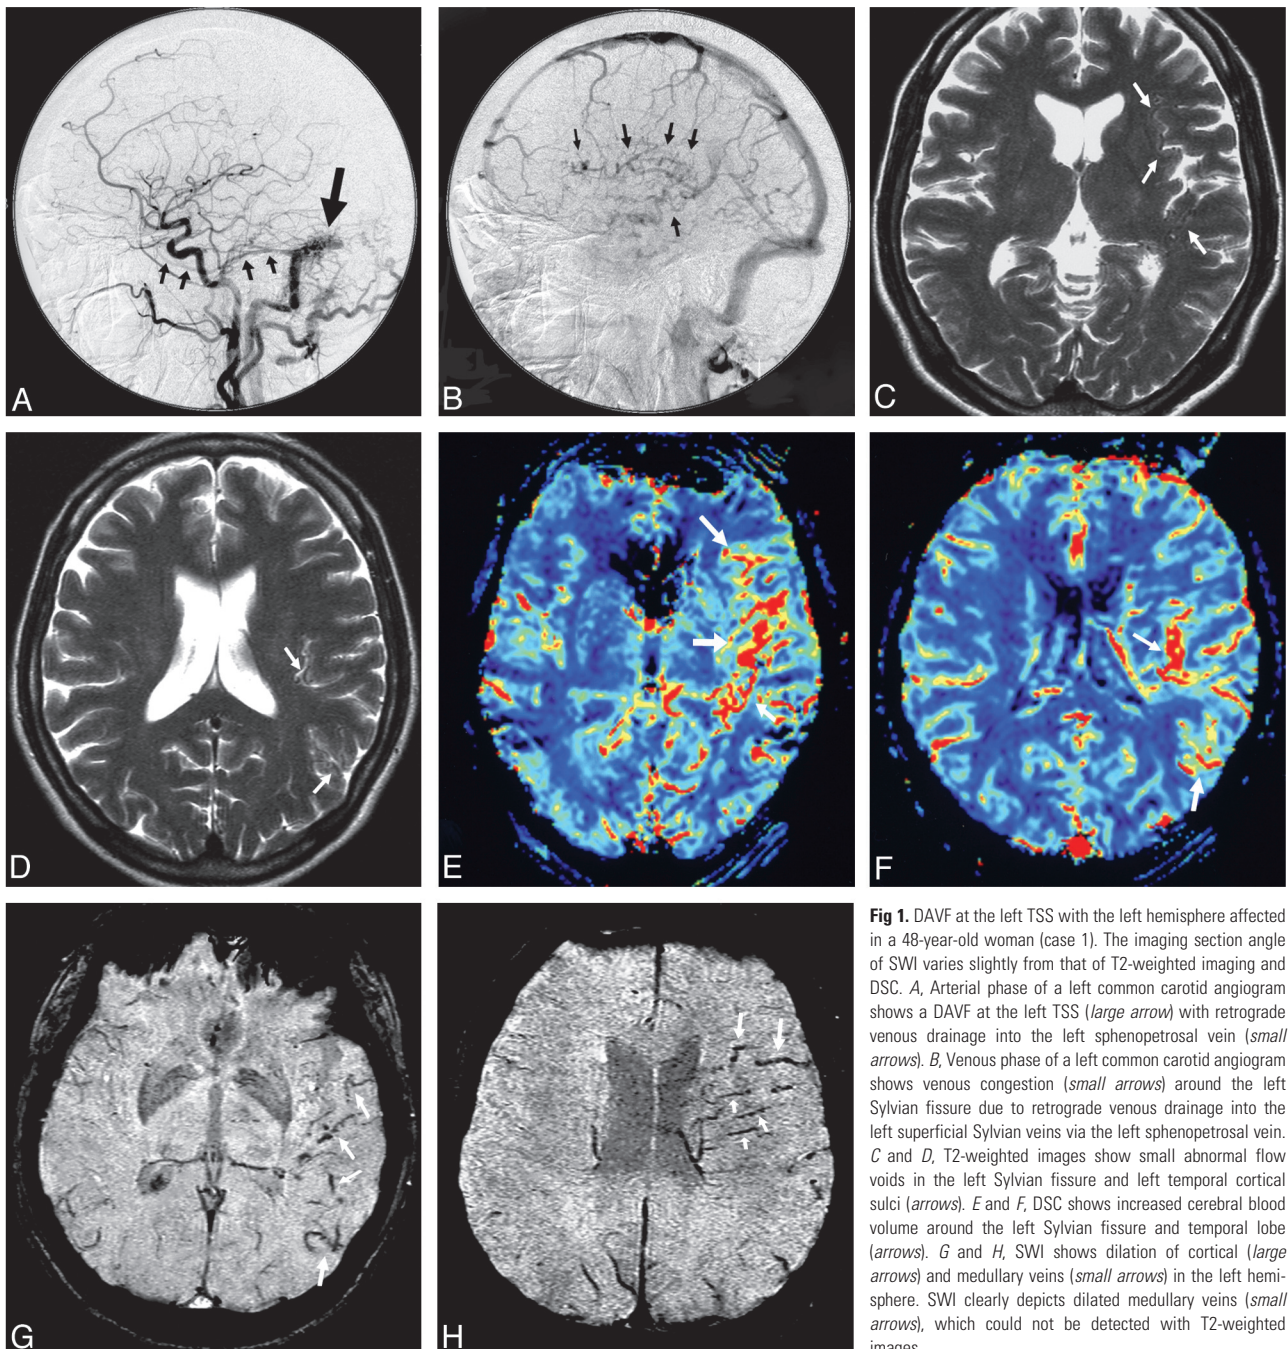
DAVF at the left TSS with the left hemisphere affected in a 48-year-old woman (case 1). The imaging section angle of SWI varies slightly from that of T2-weighted imaging and DSC. *A*, Arterial phase of a left common carotid angiogram shows a DAVF at the left TSS (*large arrow*) with retrograde venous drainage into the left sphenopetrosal vein (*small arrows*). *B*, Venous phase of a left common carotid angiogram shows venous congestion in the left Sylvian fissure and left temporal cortical sulci (*arrows*). *C* and *D*, T2-weighted images show small abnormal flow voids in the left Sylvian fissure and left temporal cortical sulci (*arrows*). *E* and *F*, DSC shows increased cerebral blood volume around the left Sylvian fissure and temporal lobe (*arrows*). *G* and *H*, SWI shows dilation of cortical (*large arrows*) and medullary veins (*small arrows*) in the left hemisphere. SWI clearly depicts dilated medullary veins (*small arrows*), which could not be detected with T2-weighted images.
